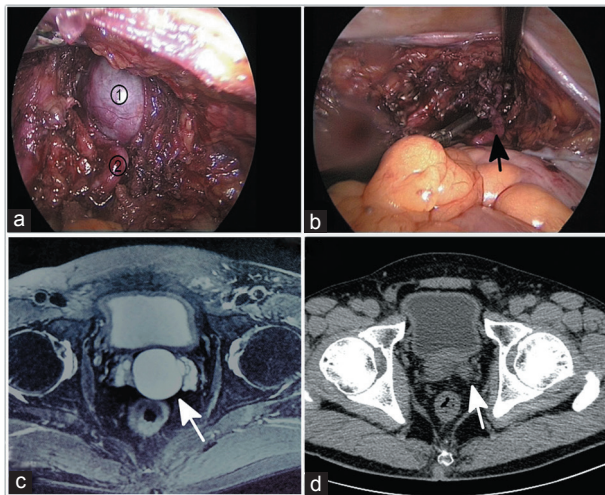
Surgical images and radiological data of transperitoneal laparoscopic unroofing. (a) The seminal cyst (1) was exposed under laparoscopic procedures, and vas deferens (2) was dissected and used as the guiding duct toward the cystic lesion. (b) The wall of seminal cyst was resected and remnant lesional rim was electrocoagulated. The vas deferens remained intact (arrow). (c) Preoperative CT image of the seminal cyst, the lesion was large and protruding into abdominal cavity (arrow). (d) The rechecking CT image took at 6 months after the laparoscopic surgery, and the cyst lesion was completely removed with no evidence of recurrence (arrow). CT: Computed tomography.
